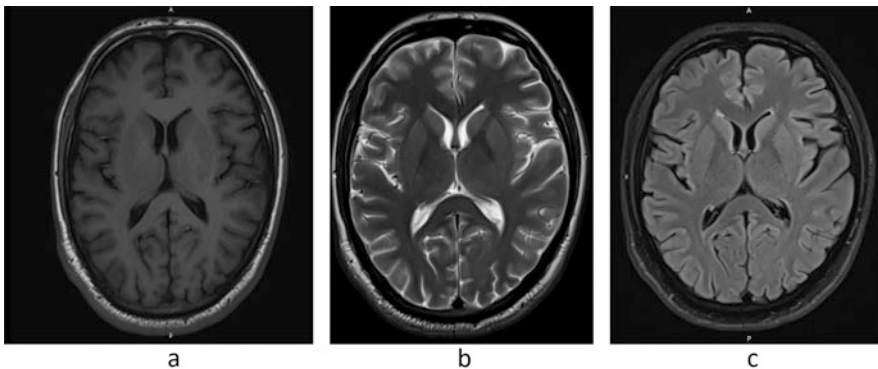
Axial MRI of brain at level of lateral ventricles showing cerebrospinal fluid as dark signal on T₁WI (a), bright on T₂WI (b) and suppression on FLAIR (c) images
